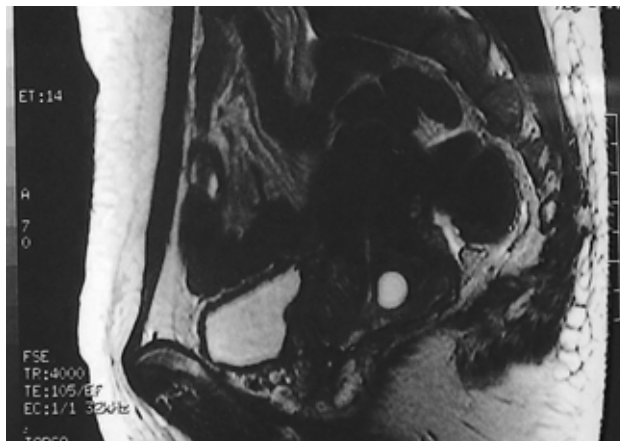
Abdomen and pelvic MRI scan shows 5.5 \times 3.5 cm high signal intensity mass in the uterine cervix.
